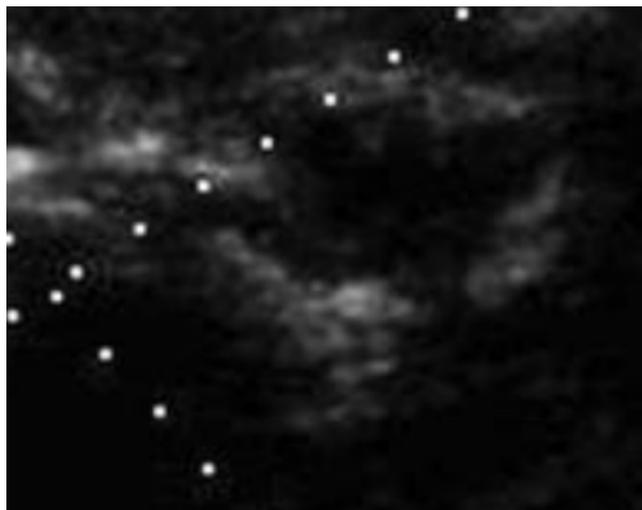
Transabdominal grayscale ultrasound image showing a heterogeneous lesion showing a solid and cystic portion arising from the right ovary.
